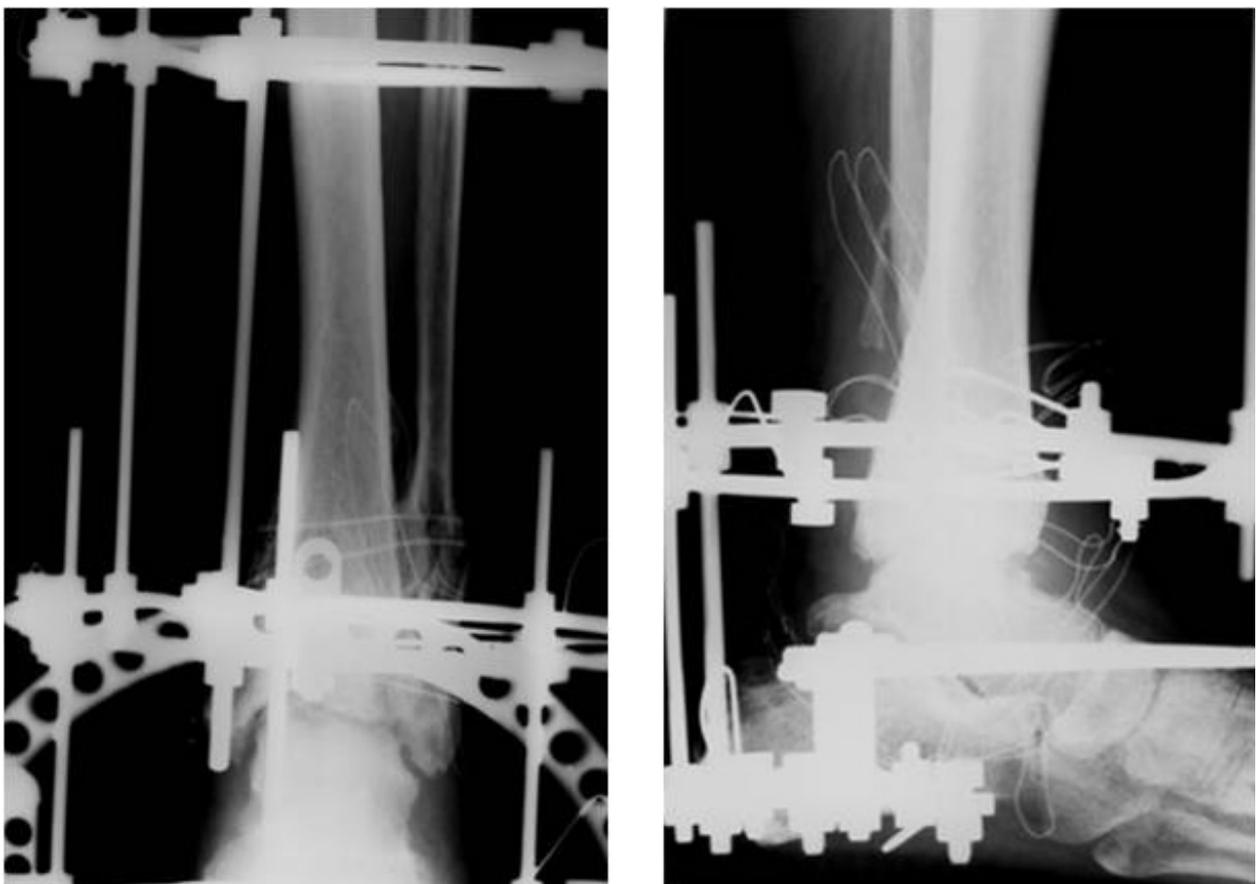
A,B: Anteroposterior and lateral X-ray pictures 2 months after the beginning of treatment.
